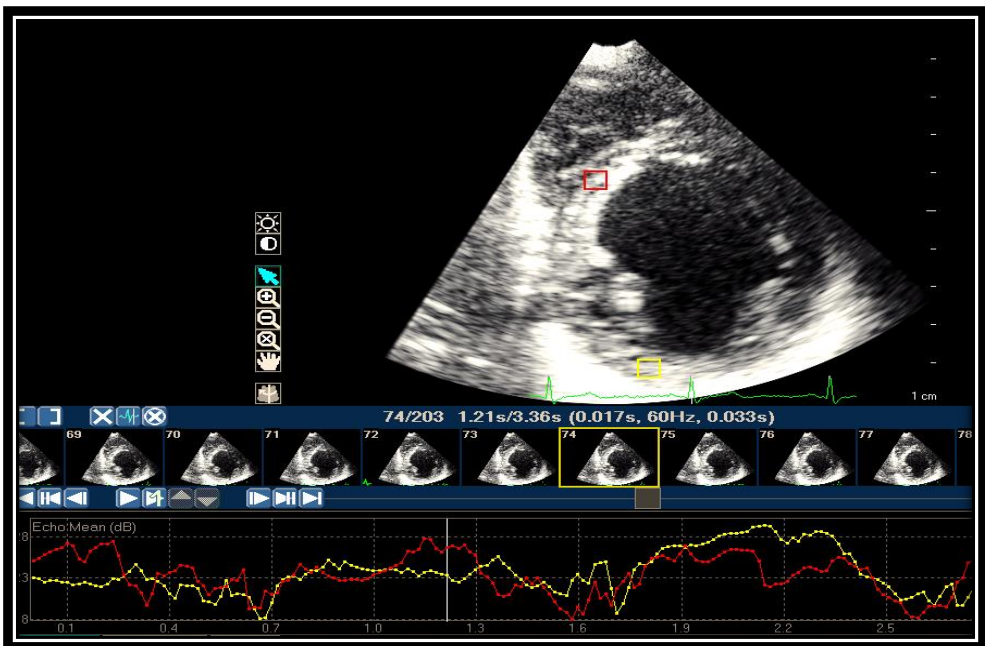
Measurement of the CVIBS. A parasternal short axis view at the level of papillary muscles is acquired for further analysis. The regions of interest were placed in the anterior septum (yellow box and line) and in the posterior wall (red box and line). After visual inspection of adequate tracking, the highest and lowest values were collected. The CVIBS was calculated as the difference between these values.
